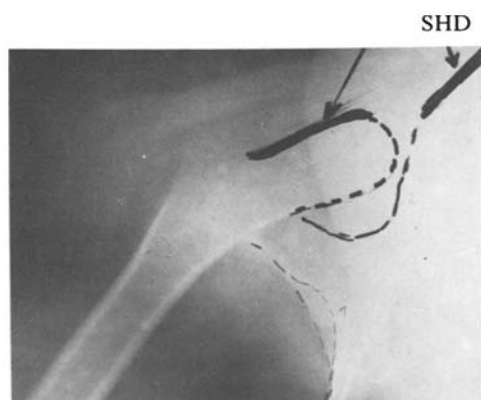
Radiograph of the left hip, position as in Fig. 13a. Distinctly interrupted SHD-line
